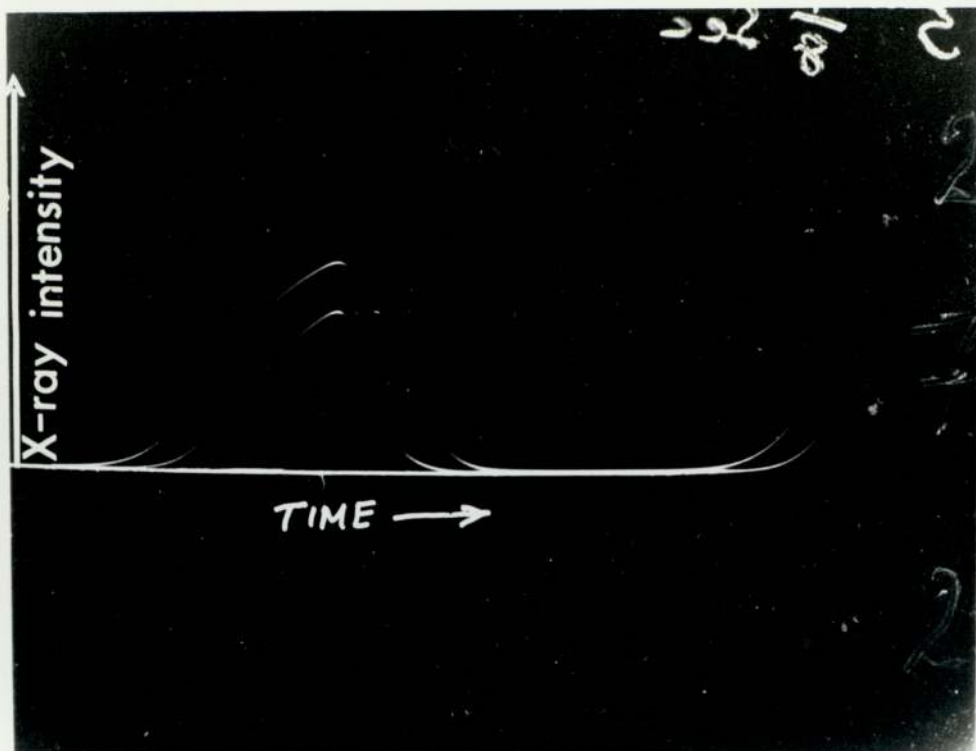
The instantaneous X-ray intensity wave forms
